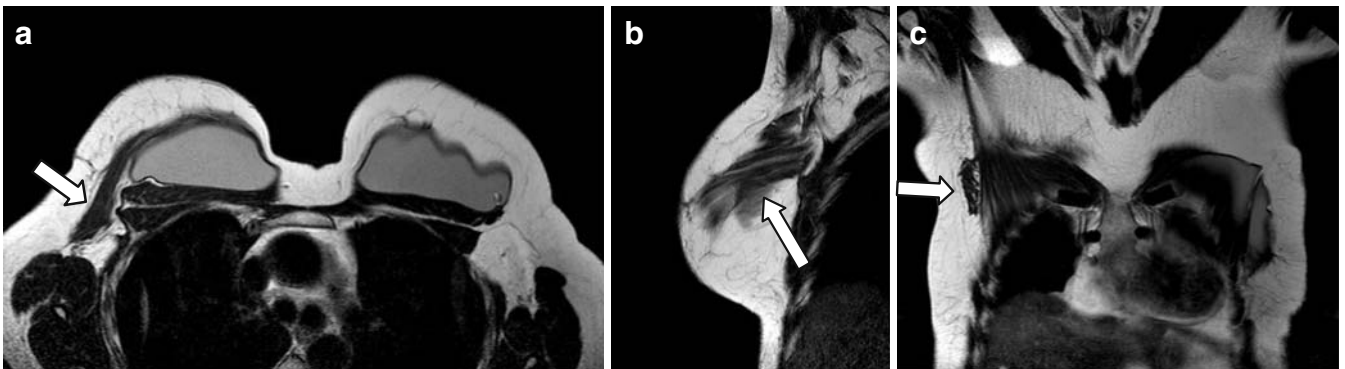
Case number 8726 of March 26th, 2009; 48 year-old patient, left radical mastectomy, breast reconstruction with *latissimus dorsi* flap and implants in 2005; T2-weighted sequences in the transverse (A), sagittal (B) and coronal (C) plans showing the *latissimus dorsi* muscle in the lateral portion of the chest wall (white arrows).
